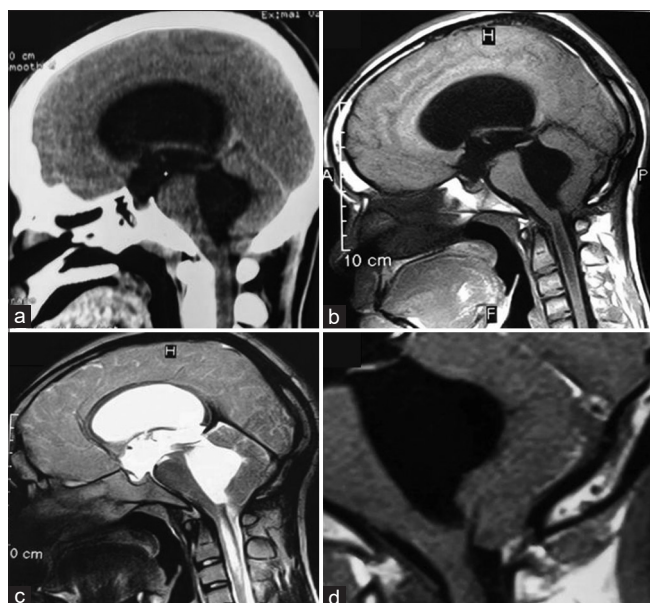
Sagittal (a) Computed tomography scan demonstrating dilation of all ventricles. Sagittal (b and d) T1-weighted, sagittal (c) T2-weighted magnetic resonance imaging showing dilation of all ventricles, Chiari malformation type I, obliteration of the retrocerebellar cerebrospinal fluid space, and syringomyelia
